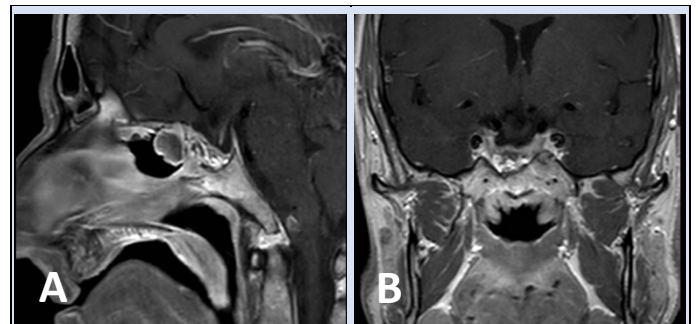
Postoperative MRI imaging of sellar region.
